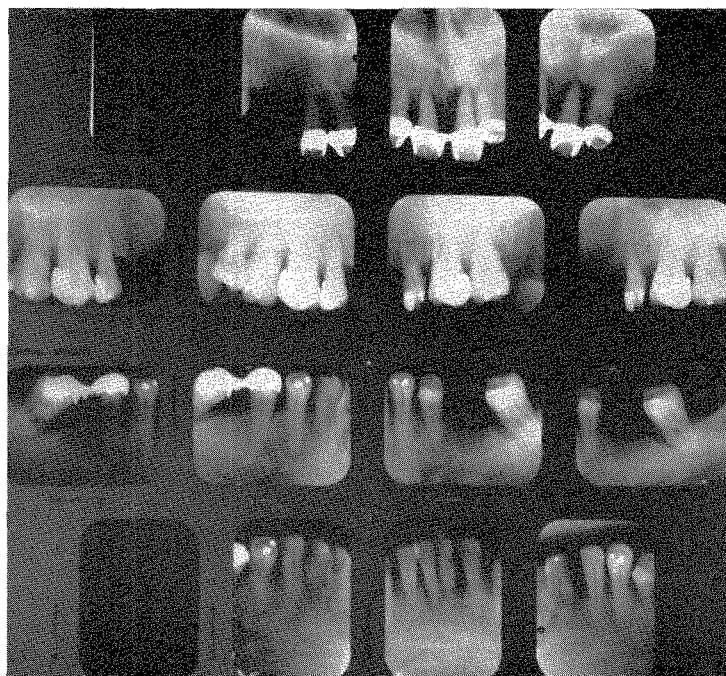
The roentgenograms that were taken in October, 1946, before the mouth rehabilitation was undertaken are shown here. There was extensive periodontal involvement.
